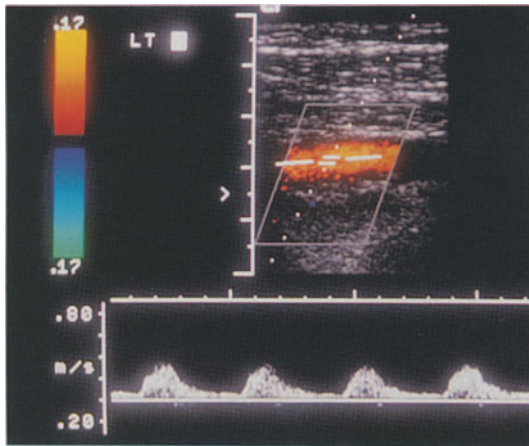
(left) Pathologic alteration of blood flow in the left subclavian artery: the Doppler waveform suggests stenosis at the origin of the vessel (proximal to the transducer), which is not visible directly. Compare this waveform with the normal example in Fig. 2
